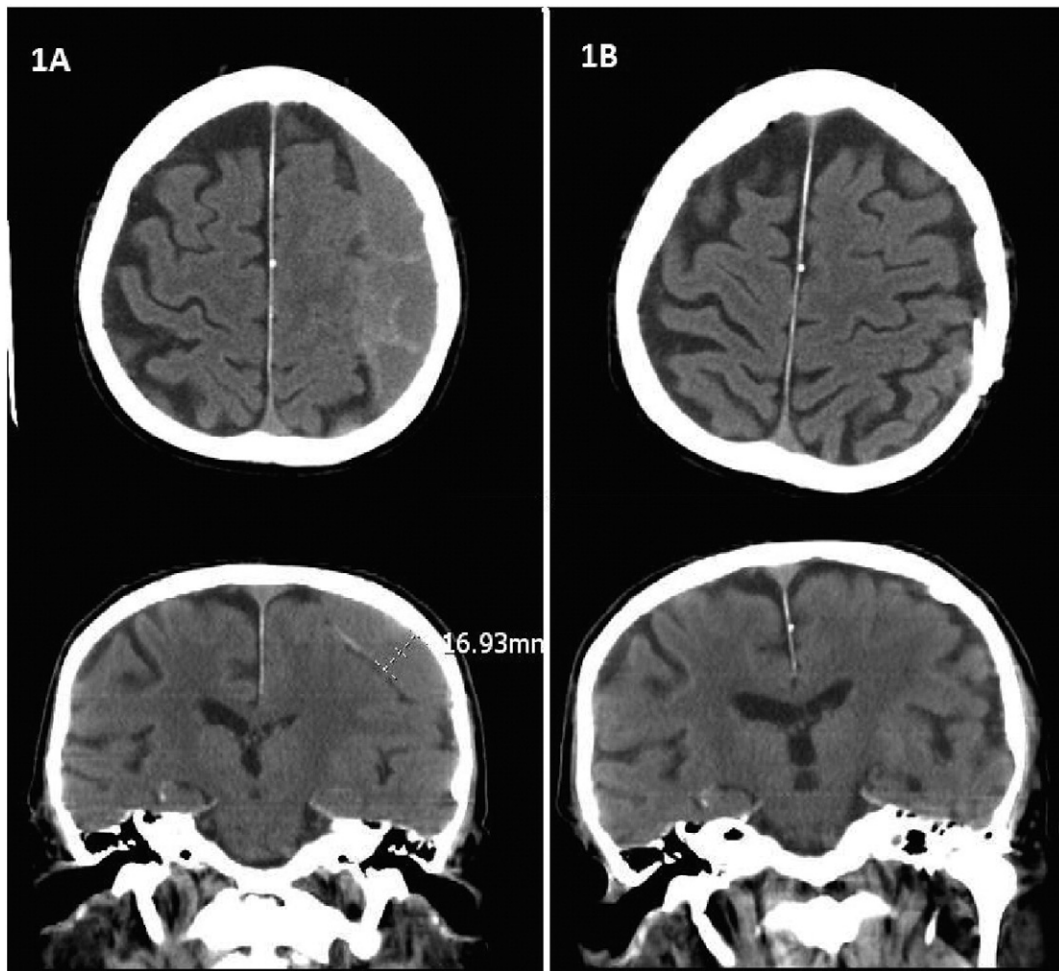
A. Brain CT scan pre-op. Image showing a large right subacute subdural hematoma causing subfalcine herniation, impending uncal herniation, right to left shift of 1.0 cm mass effect and ipsilateral ventricles. B. One-month status-post neurosurgical evacuation of right subdural hematoma. Burr hole is present at the parietal convexity. Subdural drainage catheter is seen, stable in position. Previously present right subdural air has resolved. No extra-axial fluid collections identified from the level of the foramen of Monro, to the convexity. No acute intracranial hemorrhage.
